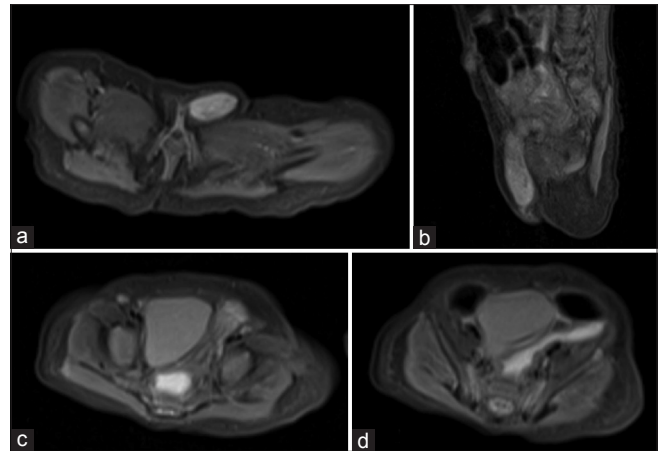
Axial short tau inversion recovery (STIR) magnetic resonance imaging (MRI) and sagittal STIR MRI images shows fluid filled sac with a heterogeneous structure in the left inguinal canal extending to left labia majora. There is suggestion of round ligament and part of uterus herniated into the sac
